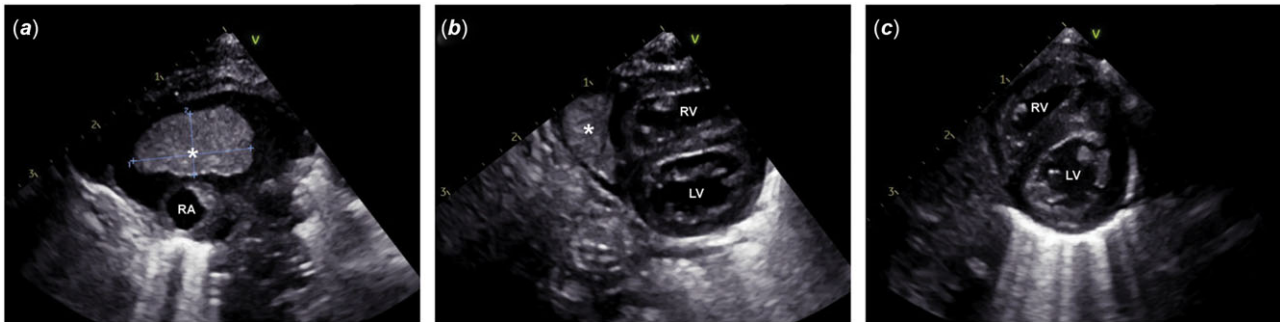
(a). Echocardiography performed after pericardiocentesis demonstrates the intrapericardial thrombus (asterisk) with a maximal diameter of approximately 8 × 15 mm and a minor residual pericardial effusion. (b). Parasternal short-axis view shows the intrapericardial thrombus (asterisk) adjacent to the right ventricle. (c). Repeat echocardiography after retransfer shows complete resolution of the intrapericardial thrombus and pericardial effusion. RA = right atrium, RV = right ventricle, LV = left ventricle.
